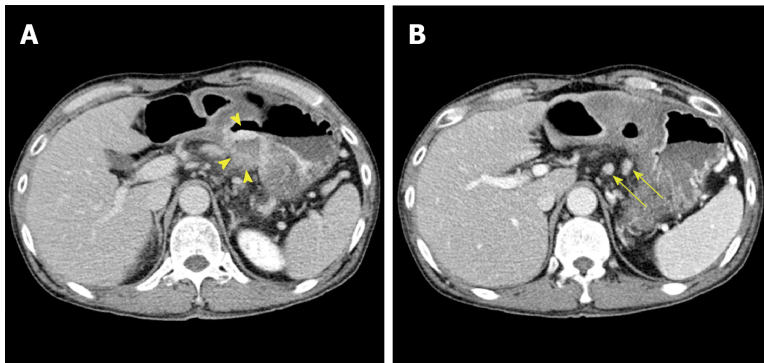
Contrast-enhanced abdominal computed tomography images. A: A huge ulcer lesion with diffuse wall thickening was detected in the posterior wall of the lower body of the stomach (yellow arrow head); B: Multiple enlarged left gastric lymph nodes were noted (yellow arrow).
